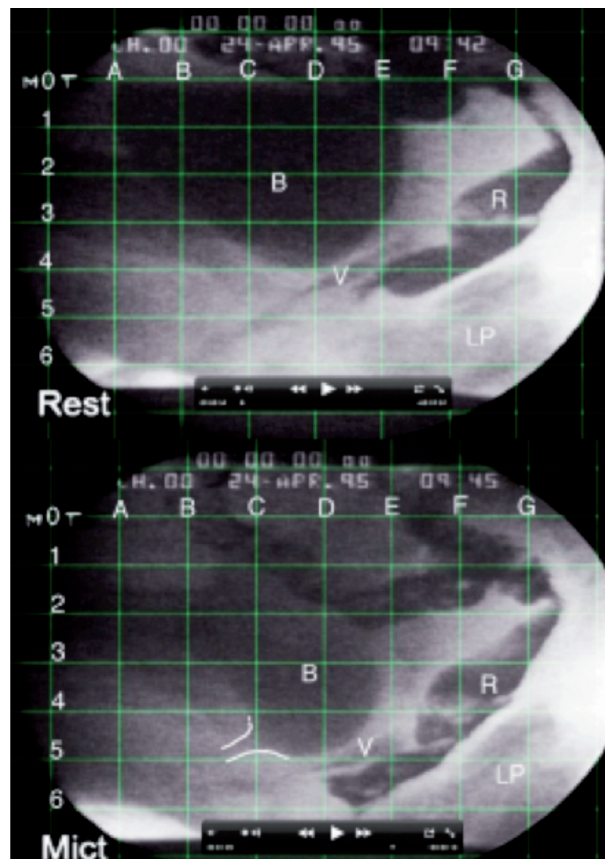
Active opening of the urethra. Video xray. The upper xray is at rest. The lower Xray was taken during micturition. Dye has been injected into bladder ‘B’, vagina ‘V’, rectum ‘R’, levator plate ‘LP’. The grid allows direct comparison of organ movement during micturition. *Micturition* The bladder base, vagina and rectum have been pulled down from level 4 to level 5, apparently by contraction and downward angulation of the levator plate by a downward vector (arrow) contracting against the cervix (CX). Compare square F-G, levels 4-5, ‘Rest’ & ‘Mict.’
